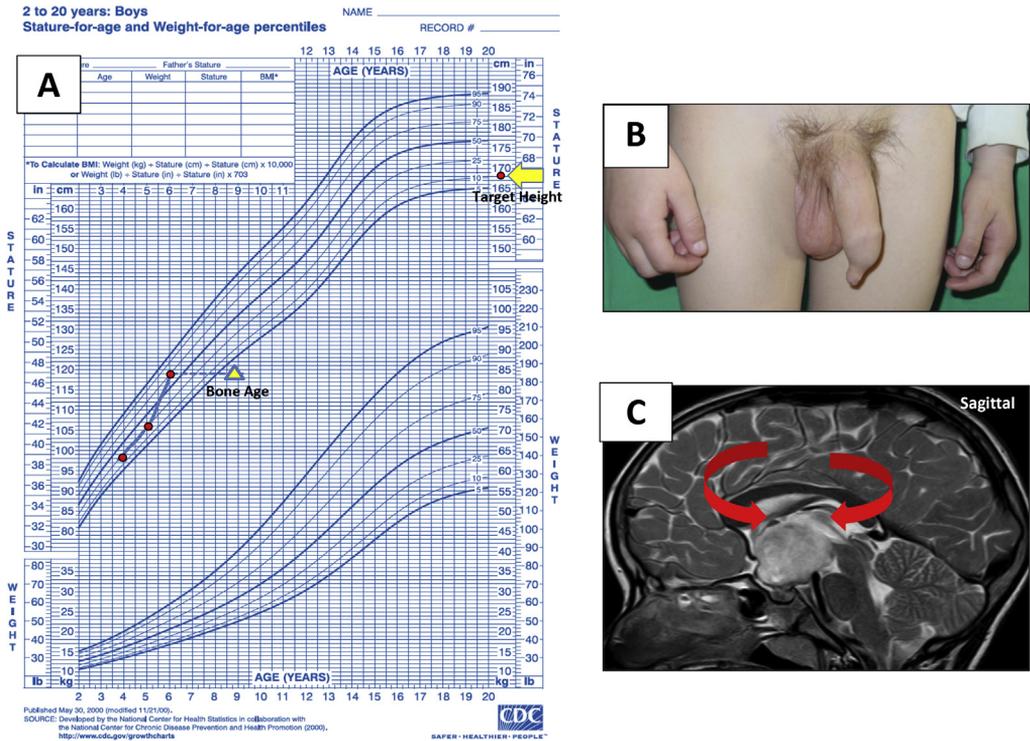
A boy with CPP diagnosed at 5 years and 11 months. At this moment, he had a BA of 8 years and 8 months and he was in Tanner stage IV. A) Growth chart: height of 116 cm (+0.2 SDS) higher than target height (-1.6 SDS). It is relevant to check the increase of growth velocity. B) Tanner stage IV: testes of 15 cc of Prader, P3 and penis enlargement. Testosterone levels were 5.2 ng/ml and the LH peak after GnRH stimulation test was 15.5 IU/L. C) Brain MRI: juvenile pilocytic astrocytoma.
